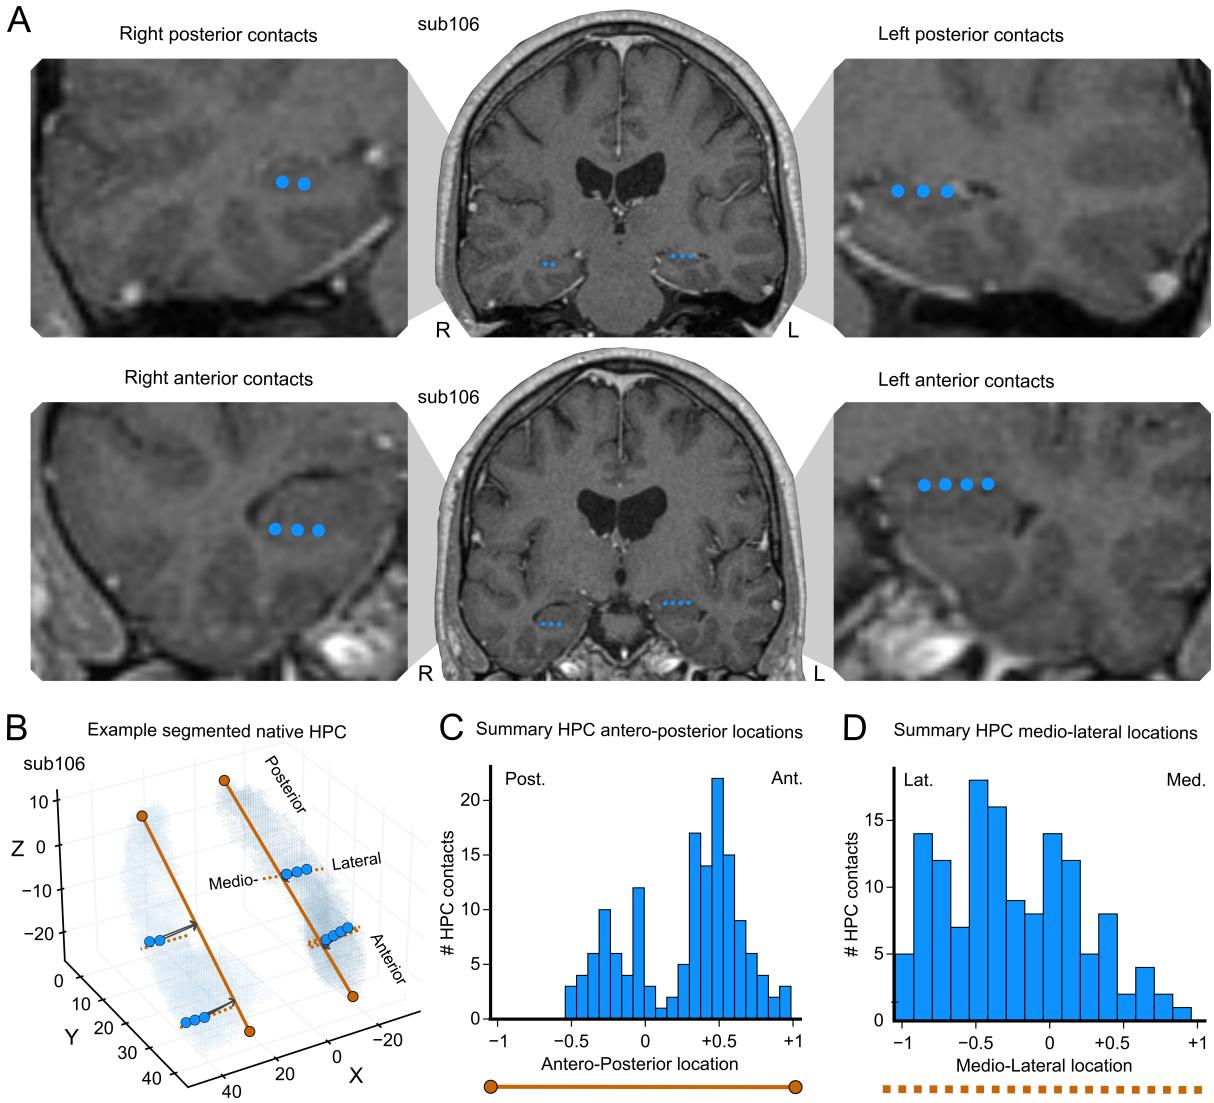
Anatomical localization and distribution of hippocampal electrode contacts (A) T1-weighted MRI showing posterior (top) and anterior (bottom) hippocampal electrode contacts. Insets display higher magnifications of the right and left hemispheres. (B) 3D hippocampal volumes segmented from the same subject's MRI with contact locations (blue dots) overlaid. Solid and dotted brown lines mark the detected antero-posterior and medio-lateral axes, respectively. (C and D) Distribution of hippocampal contacts along the antero-posterior (C) and medio-lateral (D) axes across all participants. Of 170 contacts, 105 were located in the right hemisphere.
